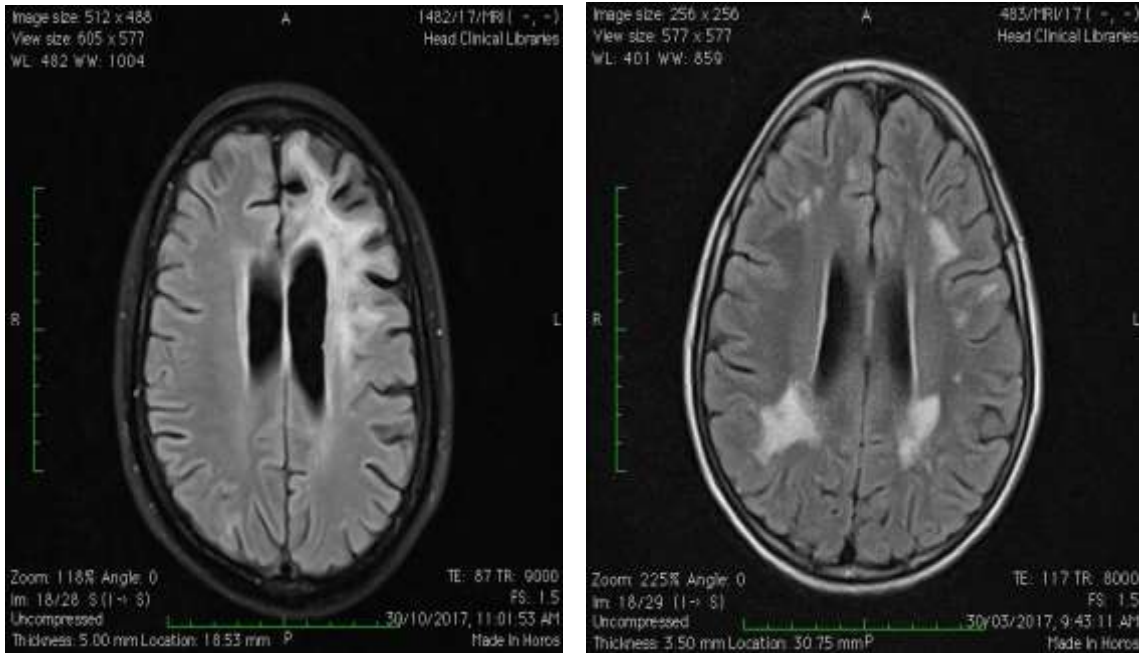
MRI findings in 2 PML patients: The axial images in fluid attenuated inversion recovery (FLAIR) show PML lesions in the left frontal lobe (left image) and in the right and left parietal lobes and the left frontal lobe of another (right image).
